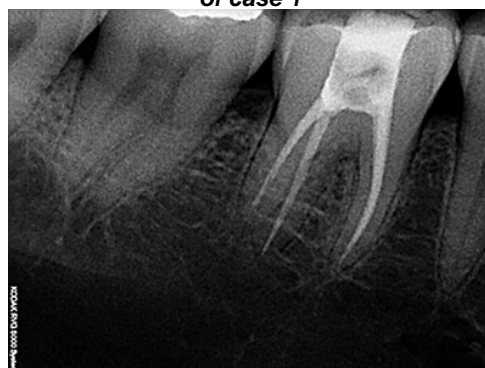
pre operative radiograph of case 1
